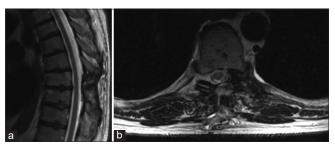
Sagittal (a) and axial (b) T2-weighted MRI images taken 2 months after the removal of a spinal MS tumor.
